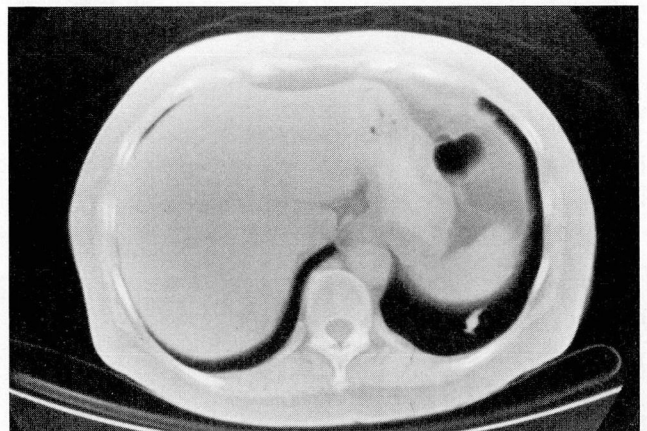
CT scan of the abdomen, showing left lower lobe nodule.
